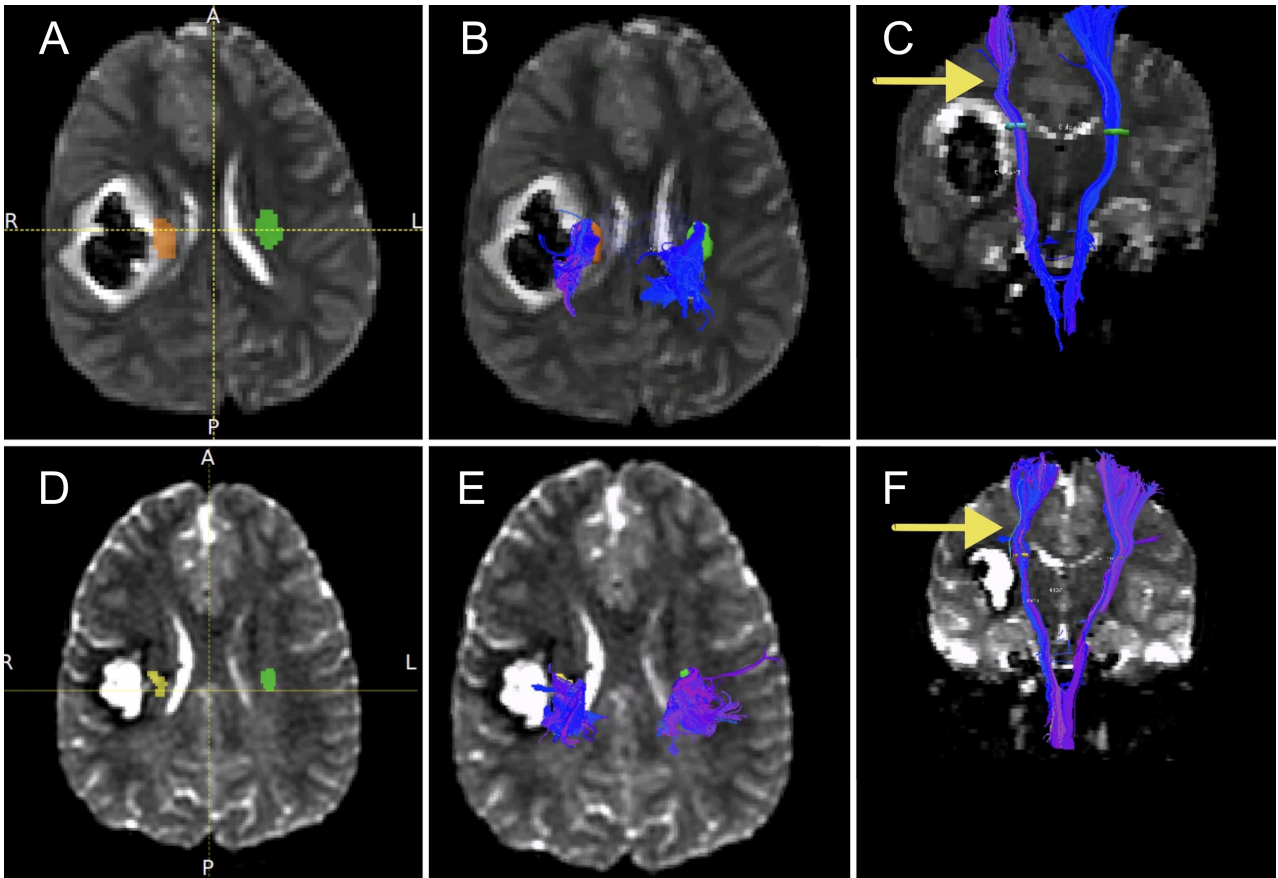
Immediate and delayed CST and motor cortex appearance on DTI. ROIs defined for right (orange) and left (green) CST seeding at the time of initial presentation on axial T2-weighted MRI (A), as well as the projected fibers in axial (B) and coronal (C) views. The decreased density of white matter tracts on the injured right compared to the contralateral side is highlighted by the yellow arrow (C). ROIs of the right (yellow) and left (green) CST 2 months after initial presentation (D) and projected fibers in axial (E) and coronal (F) views. The difference in fiber tract density is less apparent, but still appreciable, at this time and is highlighted again by the yellow arrow (F).
